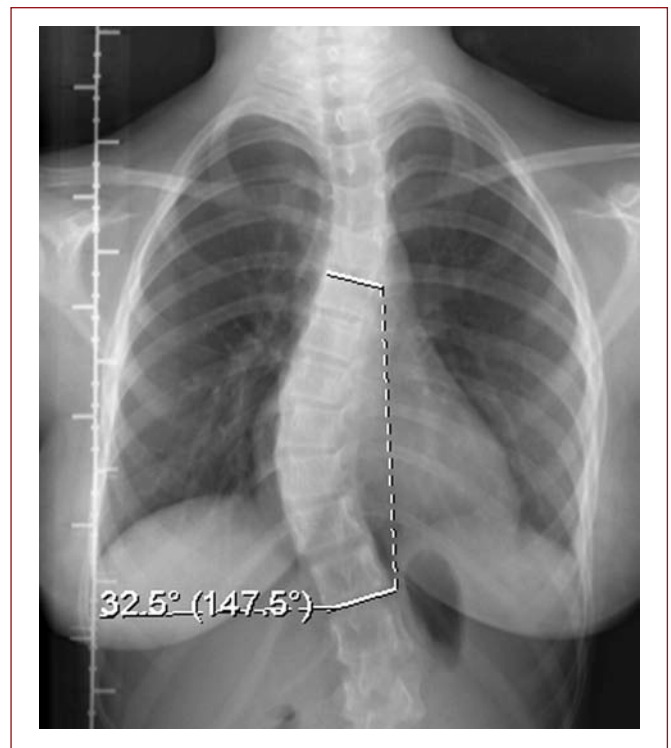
32.5° of scoliosis visible by thoracic X-ray in a 10-year-old female patient with ASD.
